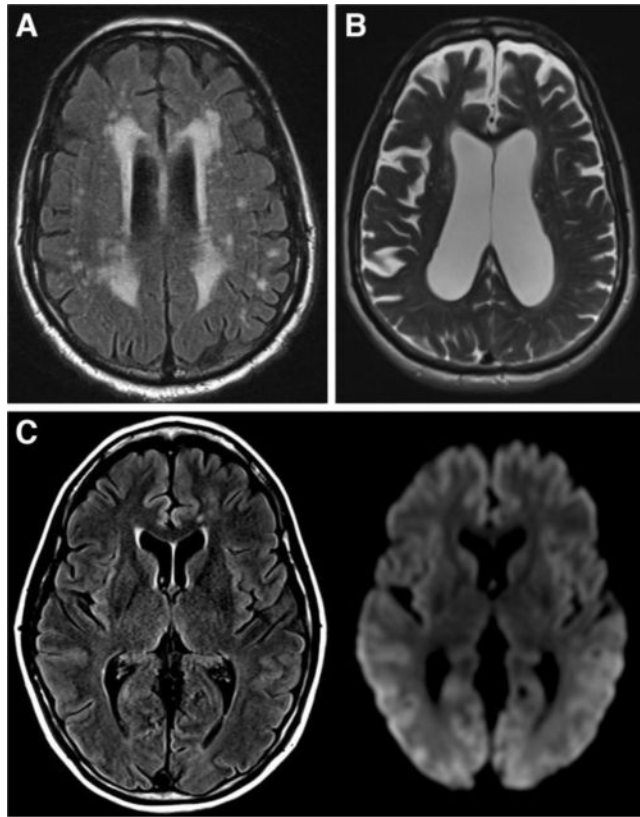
MRI appearance of selected secondary causes of dementia. (A) Marked small vessel ischemic changes manifested by confluent periventricular hyperintensity and subcortical lesions on axial FLAIR. (B) Axial T2 shows enlarged ventricles in a patient with normal pressure hydrocephalus, out of proportion to the degree of diffuse atrophy. (C) Axial FLAIR and diffusion weighted images in a patient with CJD show diffuse cortical and asymmetric deep gray matter signal abnormality most evident on diffusion imaging.
